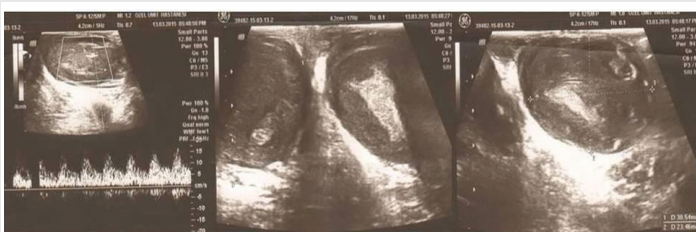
Gray-scale ultrasound images showing solid, ill-defined, hypoechoic masses in both testes replacing three-quarters of the normal testes parenchyma.
